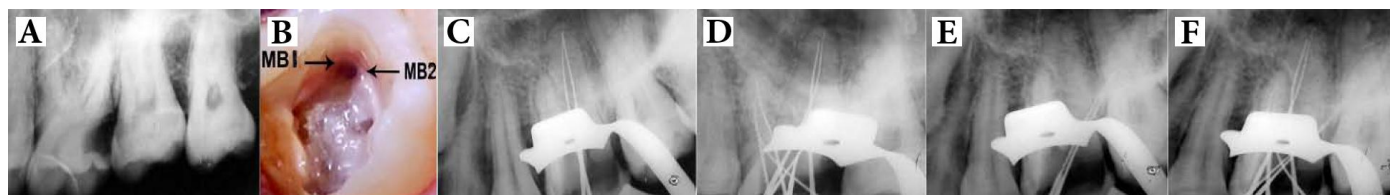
A) Preoperative radiograph of a maxillary first molar; B) Initial access opening; C-F) Eccentrically angulated radiographs to confirm the working length in the; C) Palatal (P) root; D) Mesio Buccal (MB) root; and E) Distobuccal (DB) root. F) Access opening showing seven canal orifices
